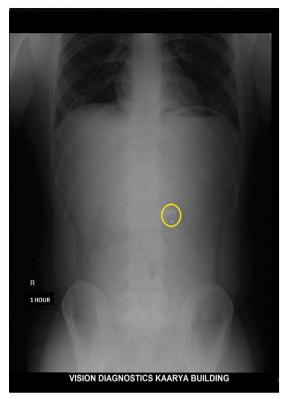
NO 8A, 8B -X-RAY
